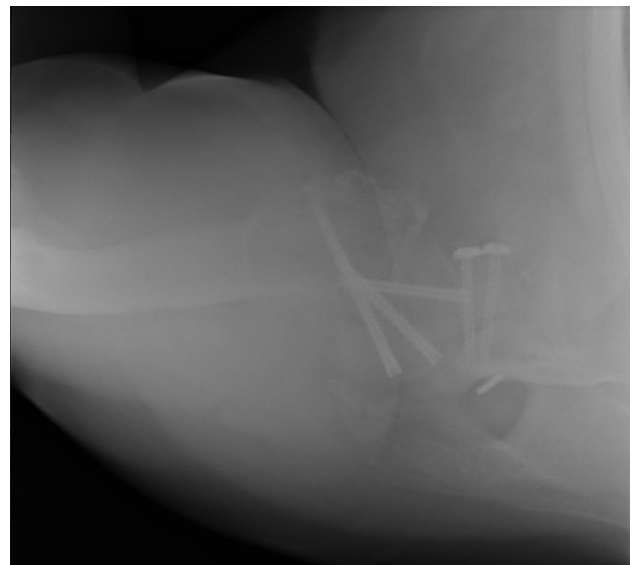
Postoperative axillary x-ray film.
